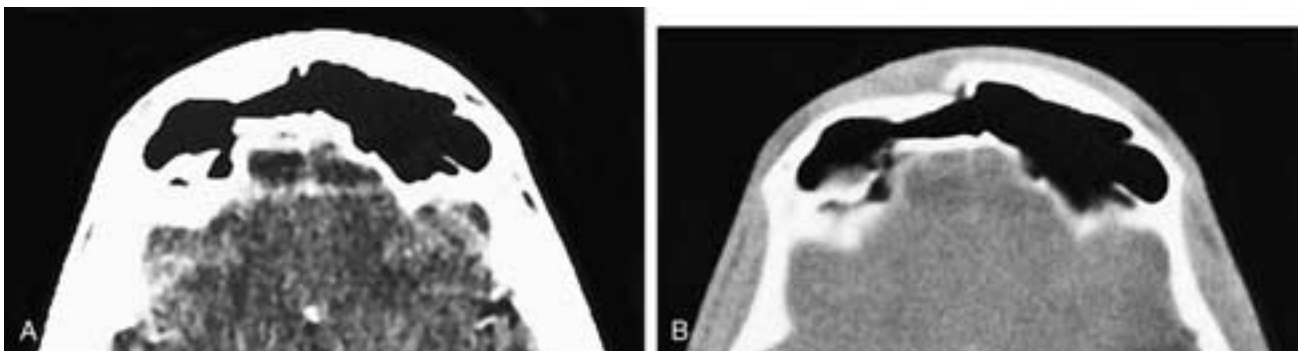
Axial CT scans seen at narrow window settings (A) and wide window settings (B). In (A) there is no obvious depression of the forehead, nor is there an obvious fracture of the right anterior frontal sinus table. In (B) the fracture is clearly seen. There was no soft-tissue depression in the forehead because the defect was filled with hemorrhage and edema fluid.
